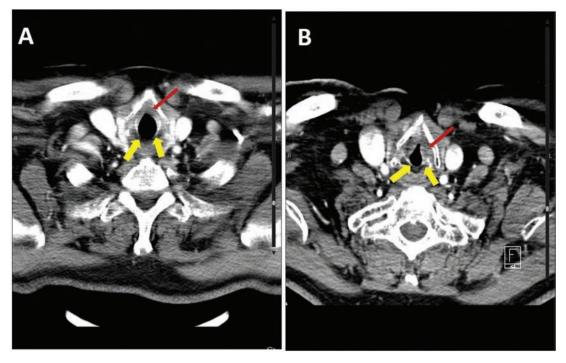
Laryngeal carcinoma and narrowing of the glottis after cervical radiotherapy. (A) CT scan with contrast performed before surgery and before radiotherapy showing a carcinoma located in the anterior third of the vocal cords (red arrow) with normal size of the glottic space (yellow arrows). (B) CT scan with contrast performed after surgery and after radiotherapy (when the patient developed stridor during sleep). The glottic space is narrower compared with prior radiotherapy (yellow arrows). Laryngoscopy showed bilateral edema (red arrow) and vocal cord abduction restriction.
